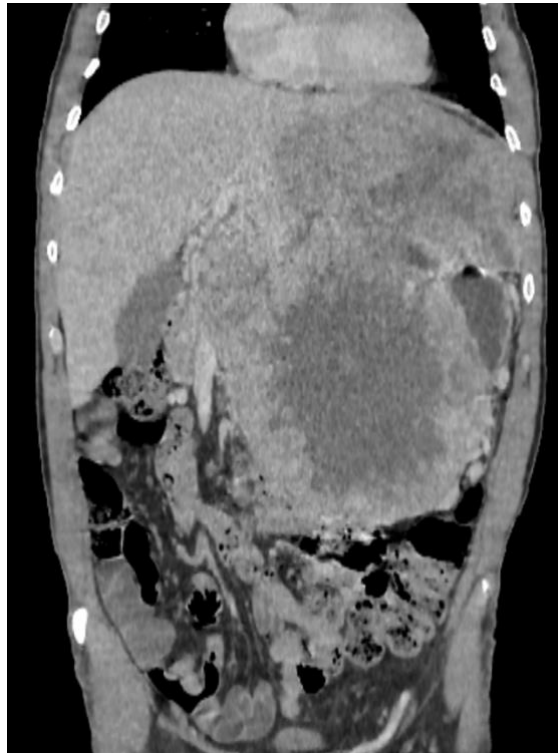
Contrast-enhanced coronal CT image showing a giant heterogeneous left intraperitoneal mass with extensive central necrosis and enhancing peripheral solid components. The lesion closely involves the left hepatic lobe and is in intimate contact with the stomach.
